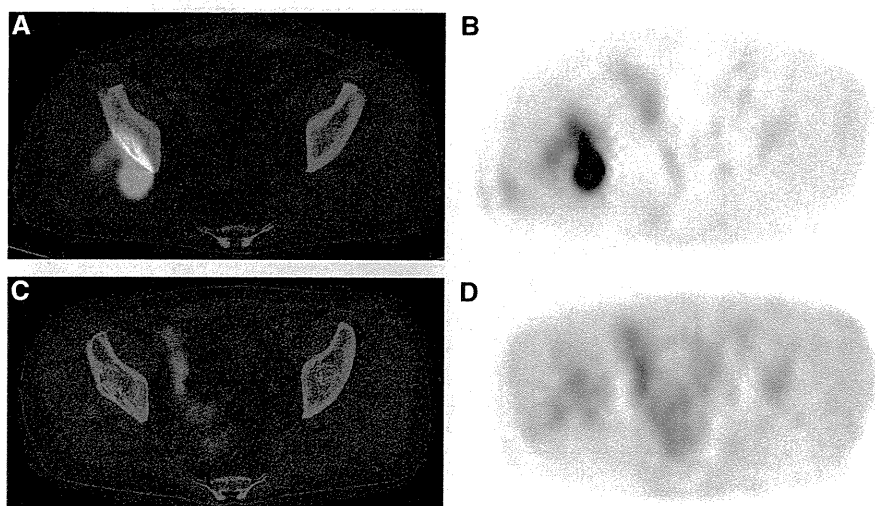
Responder of neoadjuvant chemotherapy. (A, B) Transaxial F-18 FDG PET/CT images demonstrate significant uptake in the tumor of the right buttock which is pathologically confirmed as pleomorphic sarcoma. (C, D) Transaxial F-18 FDG PET/CT images demonstrate metabolic reduction in the tumor of the right buttock after neoadjuvant chemotherapy.
